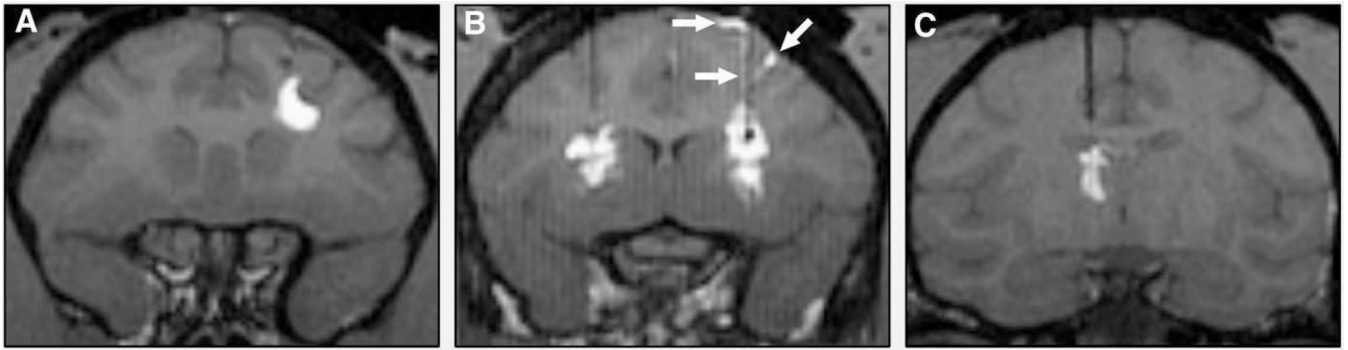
T1-weighted MR images of NHP RCD with GDL tracer. (A) Corona radiata. (B) bilateral putamen. (C) Thalamus. GDL contrast leak/reflux into subarachnoid space and along cannula tract (white arrows) is demonstrated in panel B.
